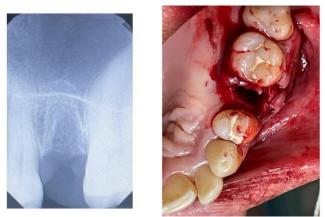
Detail of the post-extraction site. Left: A periapical radiograph was taken after the procedure. Right: Occlusal view of the surgical site.
